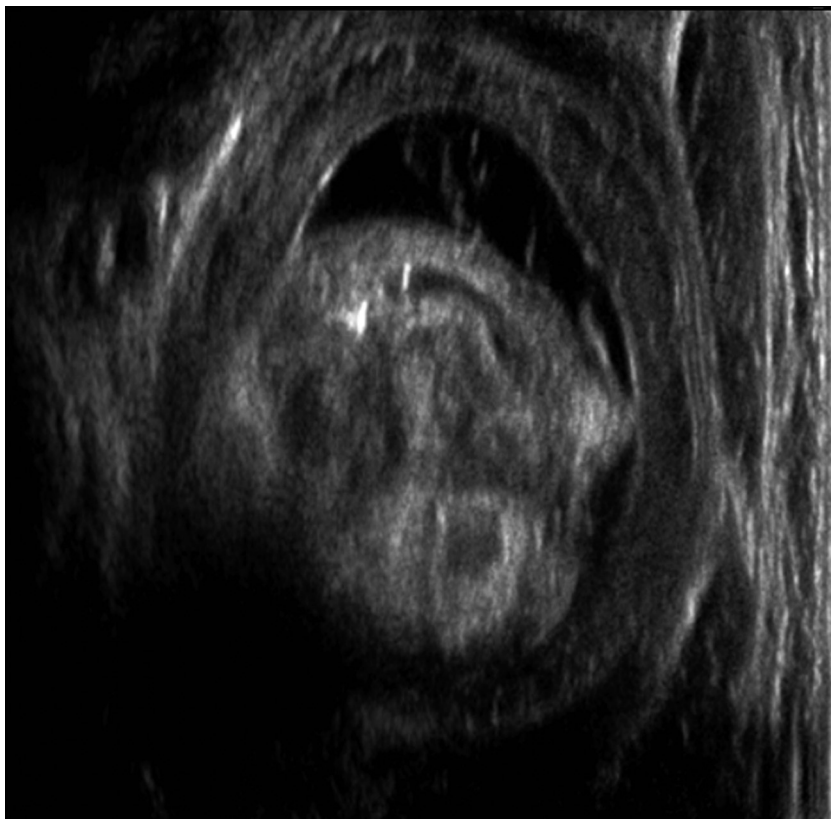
A 9-month-old girl who has had intermittent episodes of lethargy with emesis. Ultrasonography reveals the "doughnut sign," commonly seen with intussusception. Courtesy of Doernbecher Children's Hospital, Portland, Ore.
